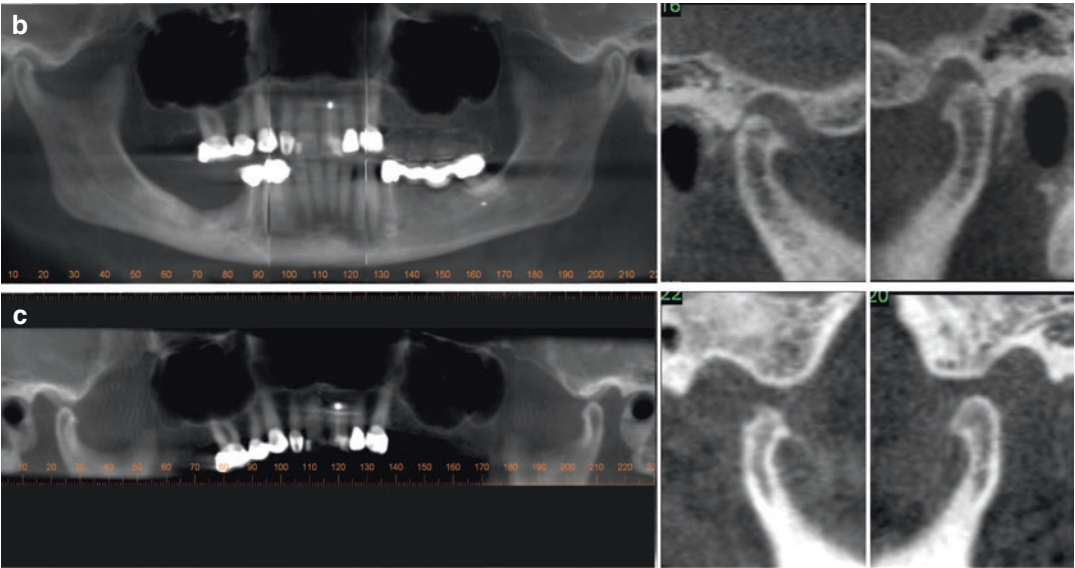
Montage of images representing some components of a typical craniofacial assessment protocol performed using moderate full FOV CBCT including volumetric and ray-sum lateral and anteroposterior projections (a), TMJ MPR (b), reformatted panoramic (c), and cephalometric analysis (d)
